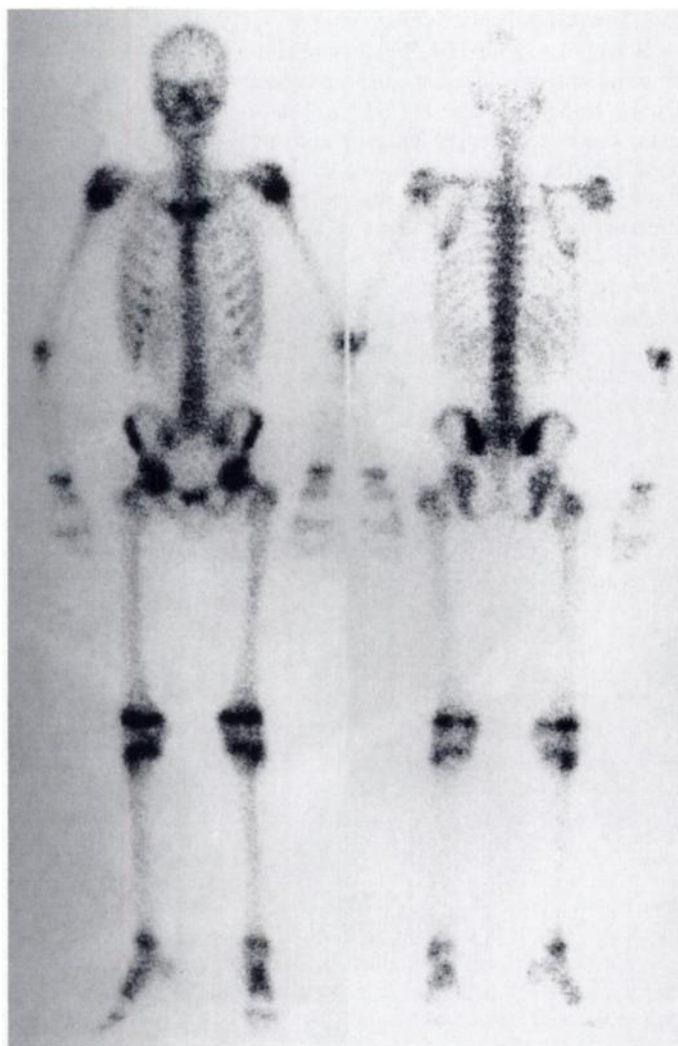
Gallium-67 scintigraphs of an 18-yr-old man with non-Hodgkin's lymphoma.
